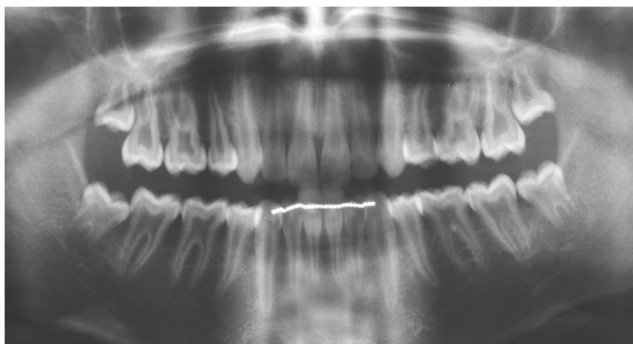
Panoramic radiograph of the patient from Fig. 2 at the age of 14 years showing numerous taurodontic molars
